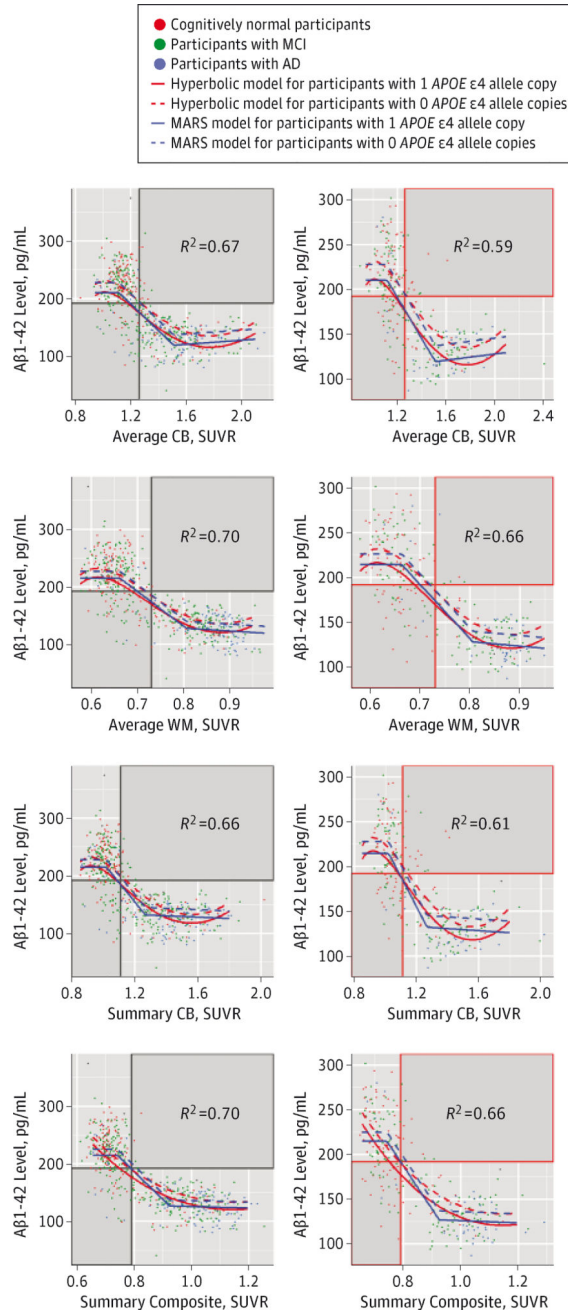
Association Between CSF Aβ1-42 Levels and Florbetapir F-18 PET SUVRs
